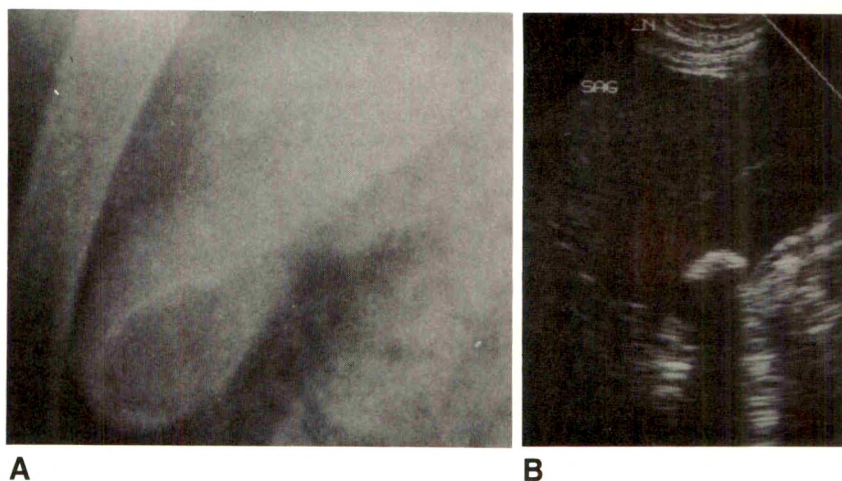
Sonographic technique, large stone: limitations of axial resolution.
